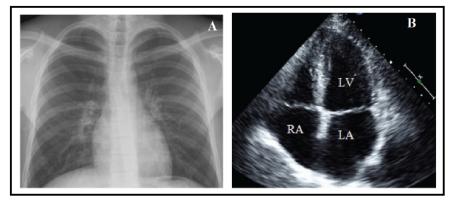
A. Chest X-Ray showed No Cardiomegaly with clear lungs B. 2D Echo revealed Normal Left Ventricle with good systolic function
